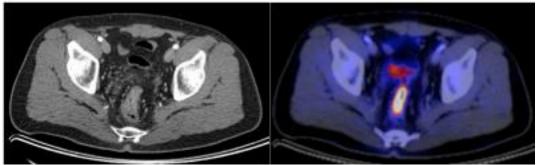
CT and fused PET/CT images that demonstrate eccentric sigmoid colonic wall thickening with increased metabolic activity consistent with the patient's known sigmoid carcinoma. Note on the CT images, soft tissue infiltration is seen beyond the colonic serosal margin indicating at least a stage 2B lesion. This case underscores the importance of evaluating both the CT and the PET images in isolation and in conjunction in order to accurately stage the patient.
